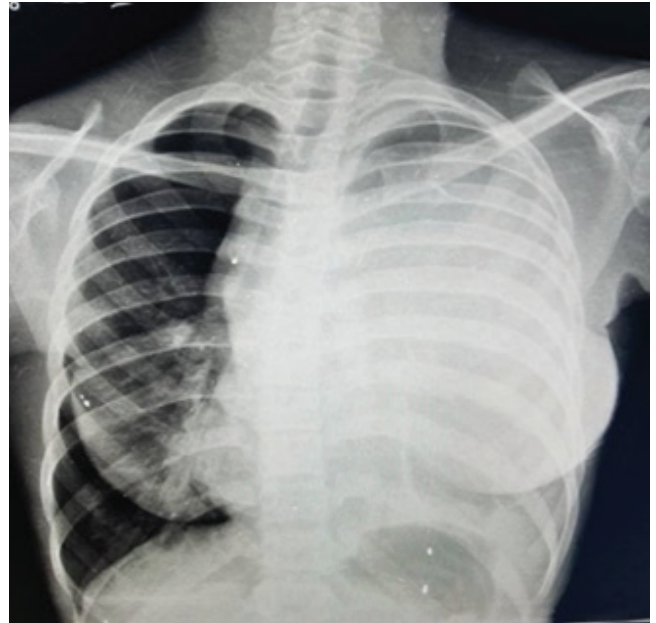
Plain chest radiograph showing a dense, homogeneous opacity throughout the left hemithorax with a massive mediastinal shift to the right, accompanied by a right-sided pneumothorax.
